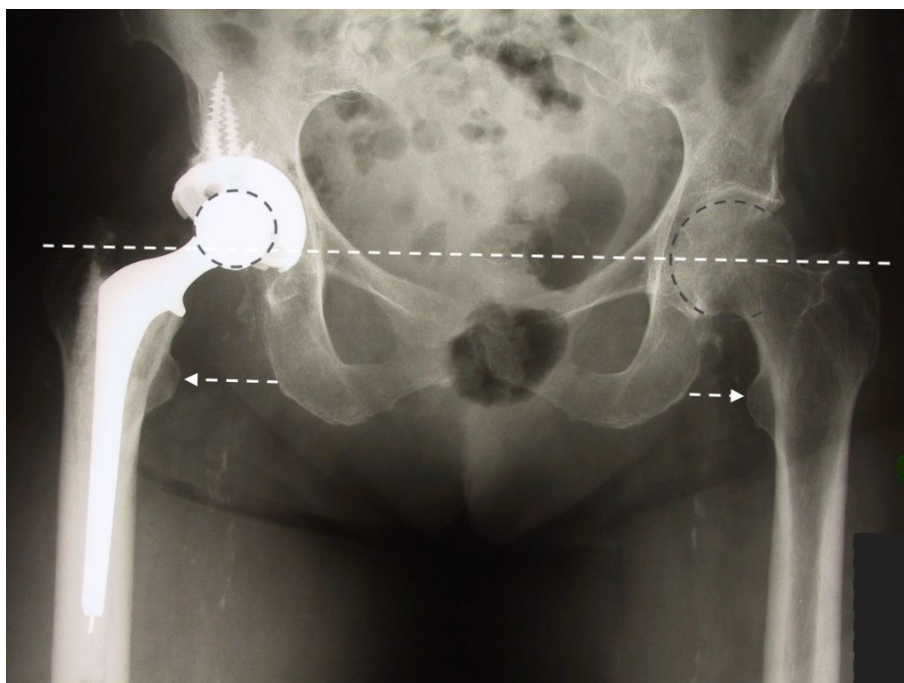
Anteroposterior pelvis radiograph of a patient complaining of right hip pain. Compared to his native left hip, the centre of rotation of the right 28mm THA was elevated, femoral offset was increased, and leg length was shortened.
